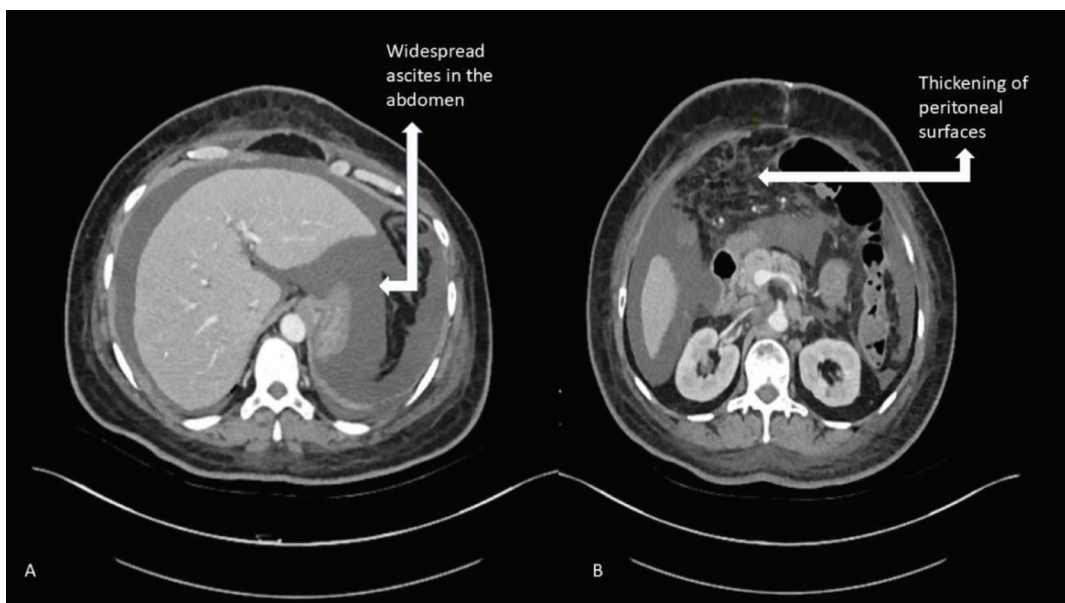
Computed tomography scan of the abdomen and pelvis: (A) widespread ascites in the abdomen, (B) thickening of peritoneal surfaces.
